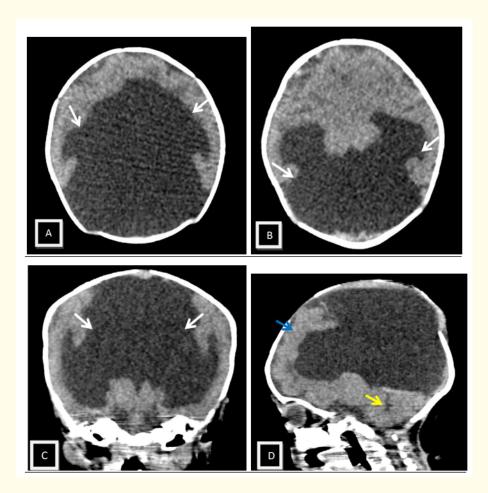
Cerebral CT scan, axial section (A, B), coronal reformatted scan(C) and sagittal reformatted scan (D), displaying a single dilated supratentorial cavity (white arrow) pushing forward the remaining cerebral parenchyma giving a "horseshoe" appearance (blue arrow). The fourth ventricle had a normal appearance (yellow arrow).
